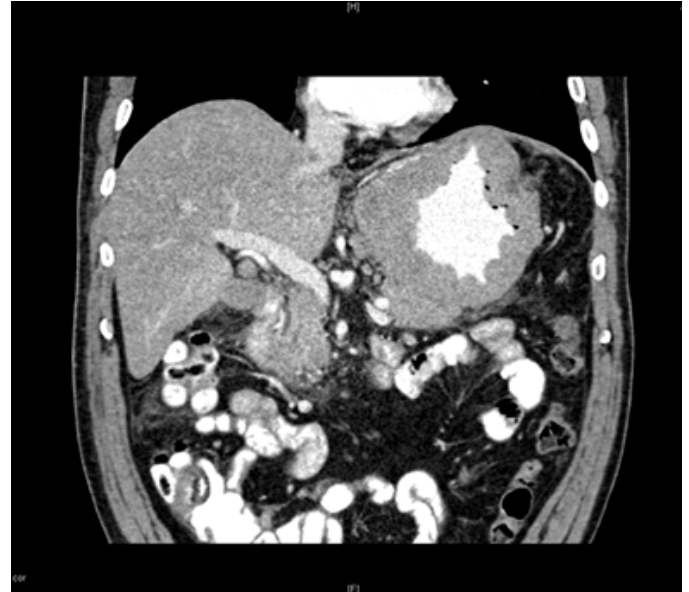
CT Abdomen/Pelvis with contrast showing thickened and irregular stomach.
